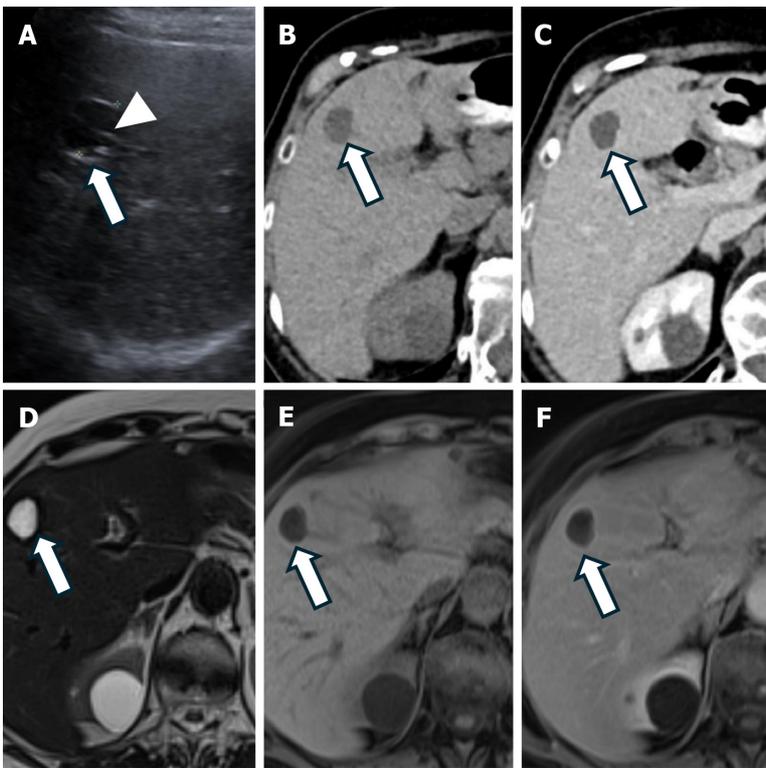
Hepatic cyst. A: Ultrasound shows an anechoic well-defined lesion (arrow) with a single thin septation (arrowhead); B: Axial non-contrast computed tomography (CT) image demonstrates a hypodense lesion (arrow); C: Axial contrast-enhanced CT image in the portal venous phase shows a hypodense lesion (arrow) with no enhancement; D: Axial T2-weighted magnetic resonance imaging (MRI) shows a markedly hyperintense lesion (arrow); E: Axial T1-weighted MRI shows a hypointense lesion (arrow); F: Axial T1-weighted MRI with an extracellular gadolinium-based contrast agent in the portal venous phase shows the lesion (arrow) with no enhancement.
